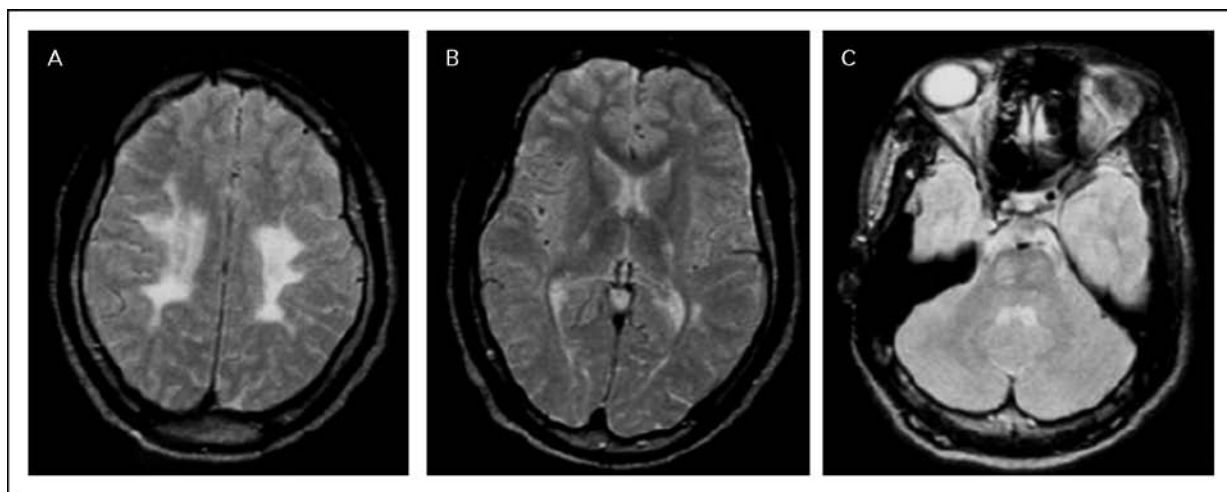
(a) Axial T2-weighted image of a 24-year-old female with Krabbe disease (globoid cell leukodystrophy) demonstrating confluent T2 hyperintensity in the bilateral centrum semiovale, centered in the frontoparietal lobes and involving the corticospinal tracts. The patient presented with a 2-year history of worsening spastic paraparesis and symmetrical lower extremity sensory disturbance. (b) Axial T2 and (c) proton-density-weighted images of the same patient showing symmetric hyperintensity in the posterior limbs of the internal capsule and pons, corresponding to the corticospinal tracts. Reproduced with permission from [49].
